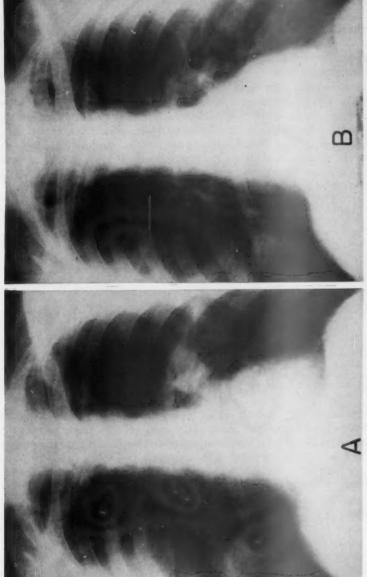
Case of destructive pneumonia with Klebsiella type 1 (or A) in the sputum. Gradual clinical and roentgenographic (see figure 2) improvement occurred on therapy with ATC (1 gm. each of oxytetracycline, chlortetracycline and chloramphenicol daily in divided doses).
